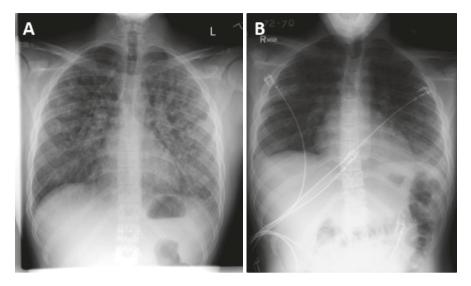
(a) Chest x-ray at the time of transfusion reaction, (b) and 72 h after transfusion
